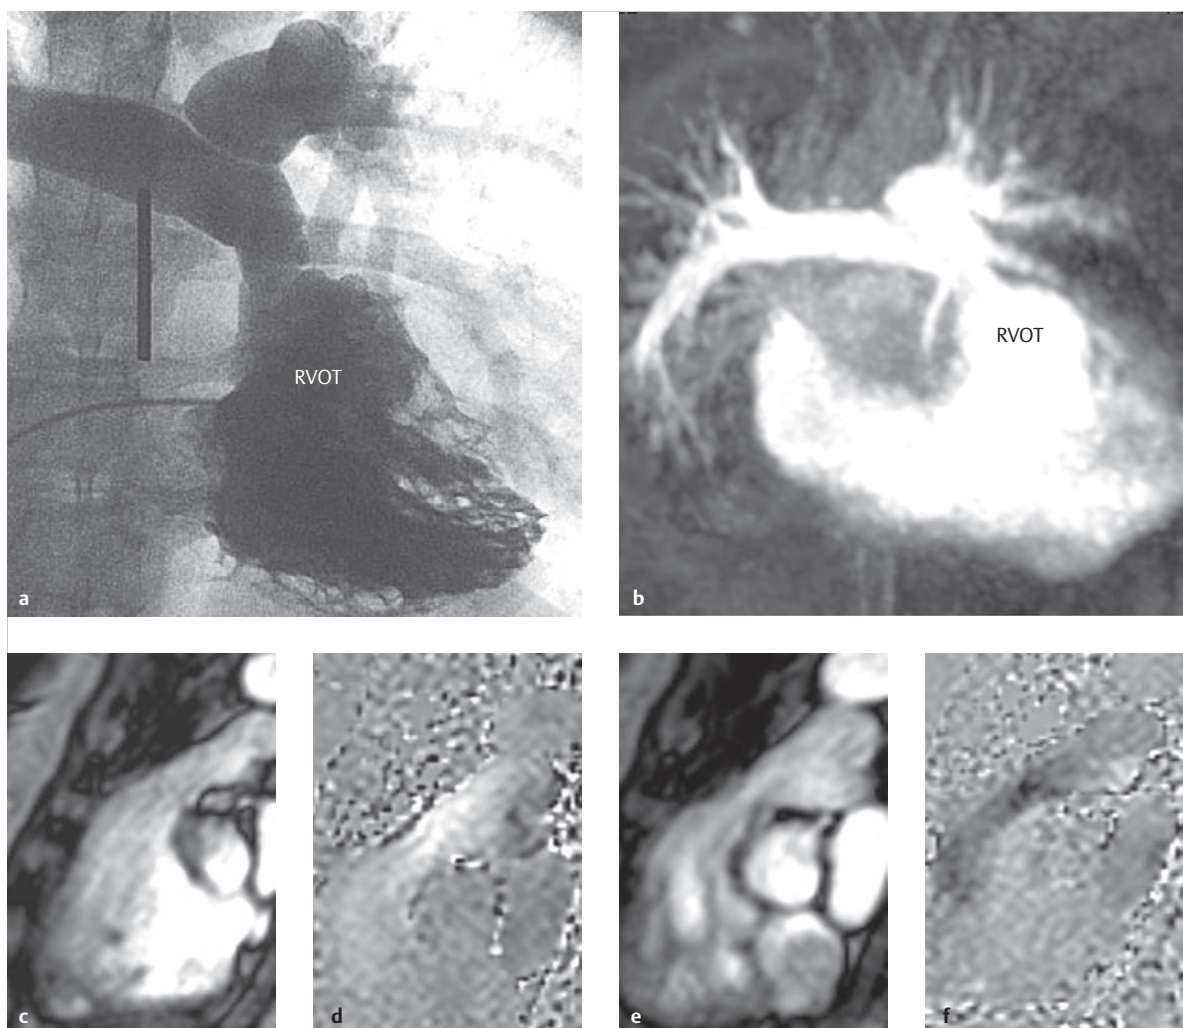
High-grade restenosis of a xenograft in the pulmonary position after correcting tetralogy of Fallot. Nineteen-year-old female patient with high-grade residual stenosis of a xenograft in the pulmonary position, after surgical correction of tetralogy of Fallot, before a planned transcatheter pulmonary valve replacement (Melody valve). Magnitude and phase images of a flow-sensitive MRI GE sequence (c–f) show flow acceleration via the stenosed pulmonary valve to a maximum of 4 m/s, in terms of a maximum estimated instantaneous pressure gradient of 64 mmHg and a holodiastolic regurgitation fraction of 39%.
